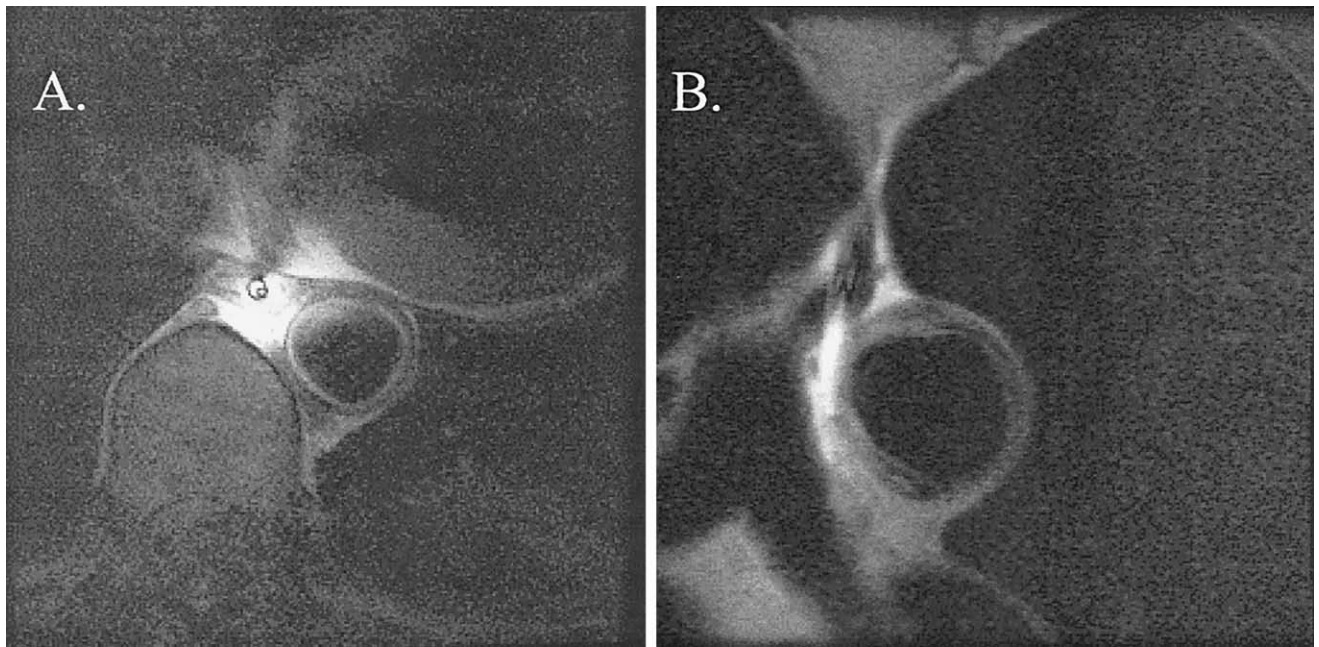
Transesophageal CMR images from two poststroke patients with increased LDL-cholesterol showing (A) homogeneous (from a 56-year-old African American hypertensive woman) and (B) heterogeneous (from a 72-year-old Caucasian man) CMR signal from thickened aortic walls. The scales are different (in actuality, the aortae have similar diameters), but the nonuniformity of wall thickness and heterogeneous signal, suggesting lipid infiltration from the patient portrayed in B, is clearly seen. In addition, these studies revealed the pitfalls of transesophageal echocardiography to assess aortic atherosclerosis caused by its near-field limitations in imaging the anterior aspect of the aortic wall.
